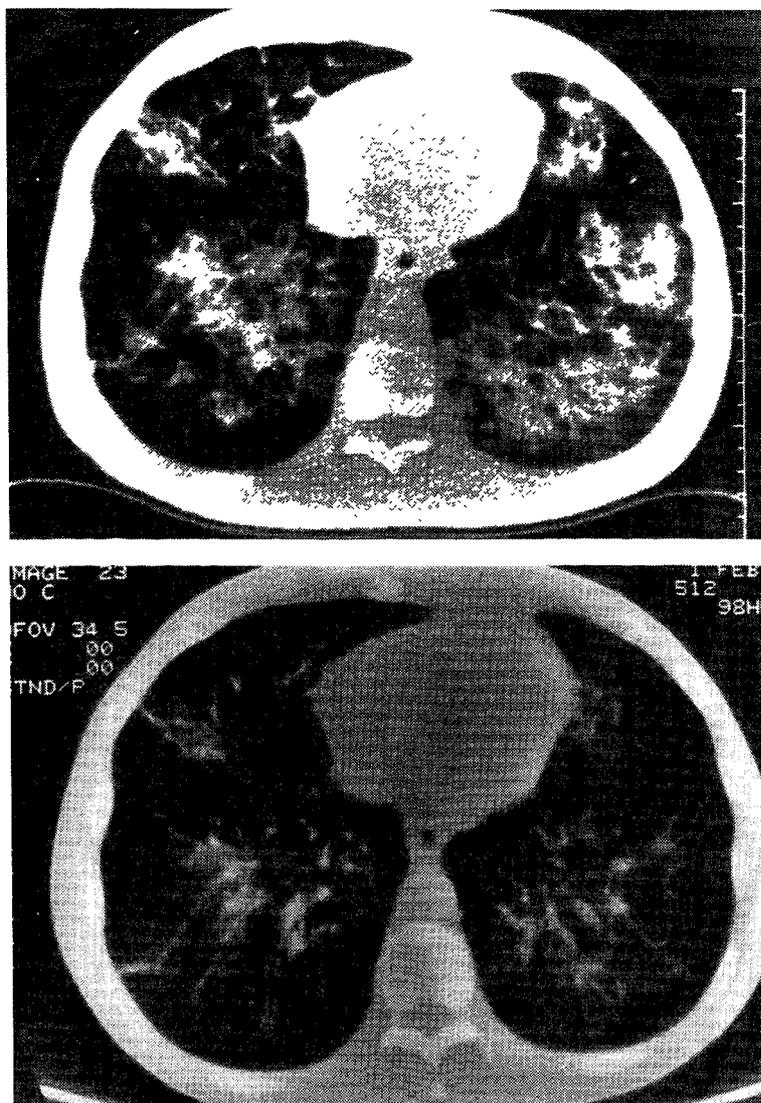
Computed tomography of patient with pulmonary Kaposi's sarcoma
